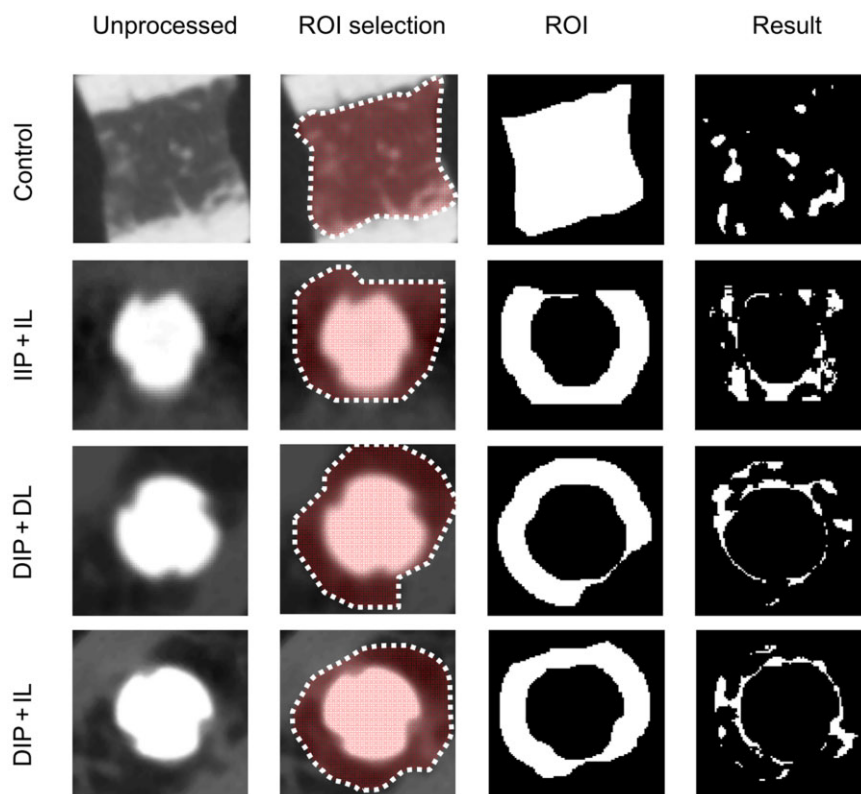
Quantification of regional bone morphometry from CBCT images for different implant protocols. From left to right: original CBCT image; manually rough selection of the region of interest (ROI) for the control (approximately 5 × 5 mm) and for the implant protocols; binary ROI automatically generated by a custom processing algorithm based on thresholding segmentation for the implant protocols, according to the specifications in Figure 3, excluding implant and cortical bone; binary segmentation of trabecular bone in this ROI, from which trabecular morphometric parameters were calculated. DIP = delayed implant placement; DL = delayed loading; IIP = immediate implant placement; IL = immediate loading.
